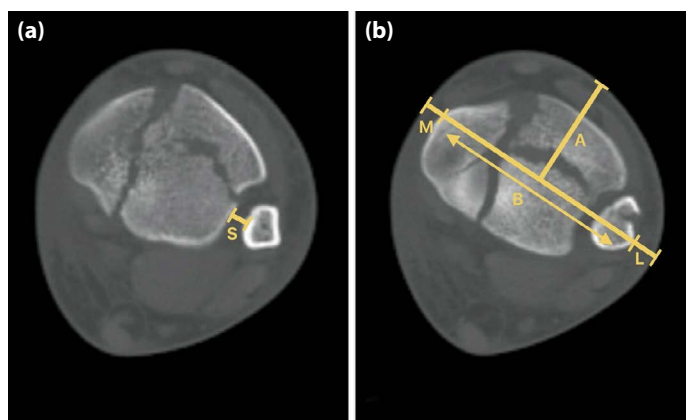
Axial computed tomography images of a 33-year-old male with a tibial pilon fracture; time to definitive fixation was 12 days. (a) Syndesmotic distance (S), measured on a slice 10 mm proximal to the joint line, defined as the shortest distance between the lateral cortex of the tibia and the medial cortex of the fibula.⁷ (b) Anterior distance (A), measured on a slice 5 mm proximal to the joint line, defined as the distance from the skin to the midpoint of the line dividing the medullae of both bones (B). Medial (M) and lateral (L) soft tissue distances represent the distances from the medial and lateral skin to line B. The bone/soft tissue ratio is calculated as $B / (B + M + L)$.
